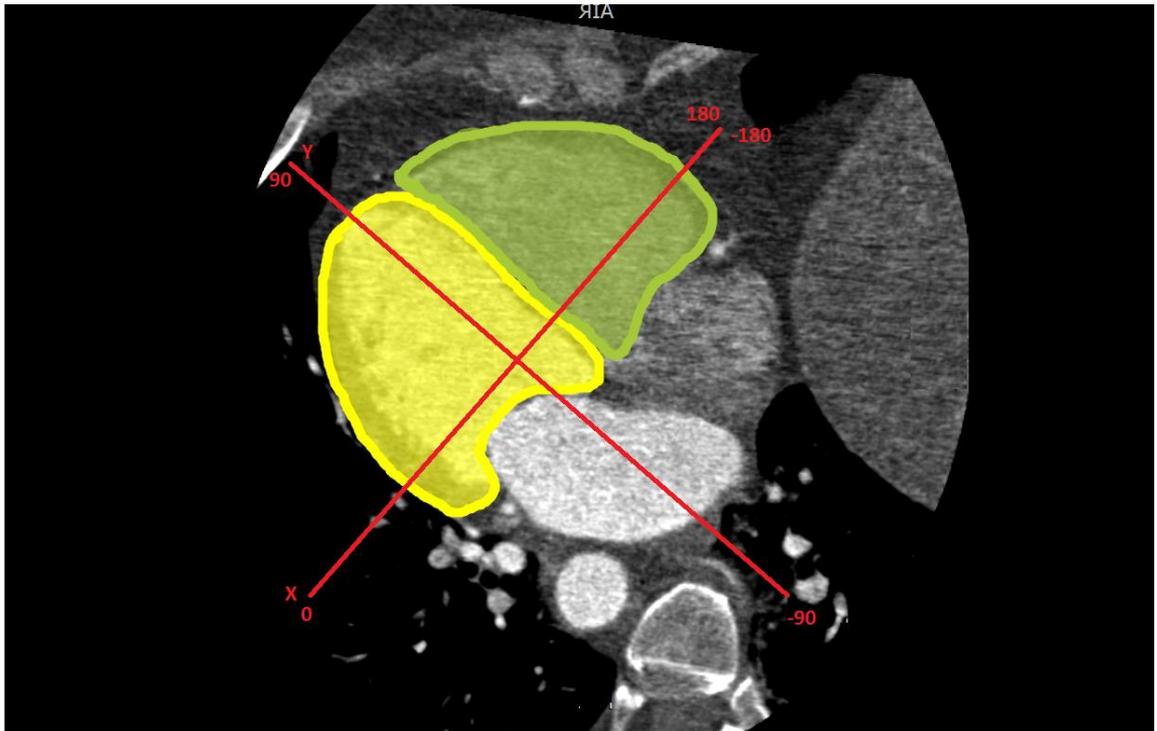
Cardiac CT section taken in the same plane as the CGM XY plane, demonstrating the orientation of the XY plane in relation to the heart in the thorax. Green shading represents the right ventricle; yellow shading represents the left ventricle. Note that the XY plane takes a long axis view through the heart, and the plane contains similar amounts of both the left ventricle and the right ventricle.
